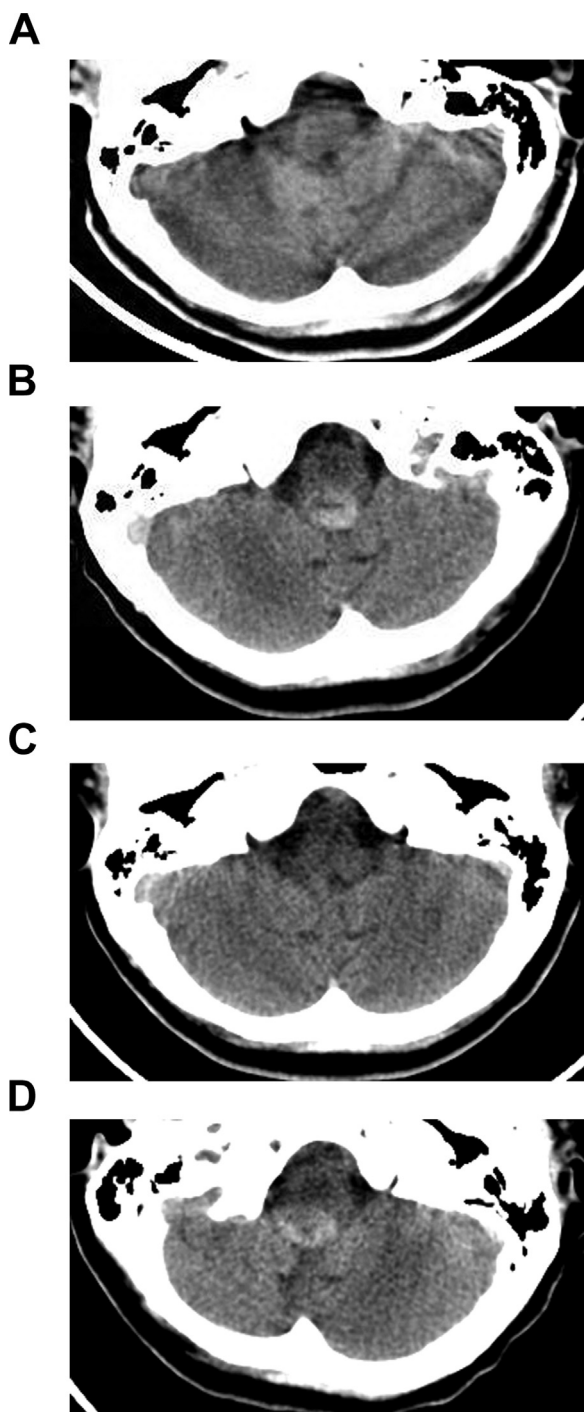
Brain CT scan performed 5 years earlier, as part of work up for an episode of seizures, shows no abnormalities in the posterior fossa (A). CT scan performed on admission showed a round intra-axial hyperdense lesion, measuring 1.4 cm × 1.2 cm × 1 cm, at the right postero-lateral medulla, just caudal to the fourth ventricle floor (B). Repeat CT brain 14 days later, upon discharge, shows resolution of the hemorrhage (C). Upon second admission, there is a new hemorrhage at the same location (D).
